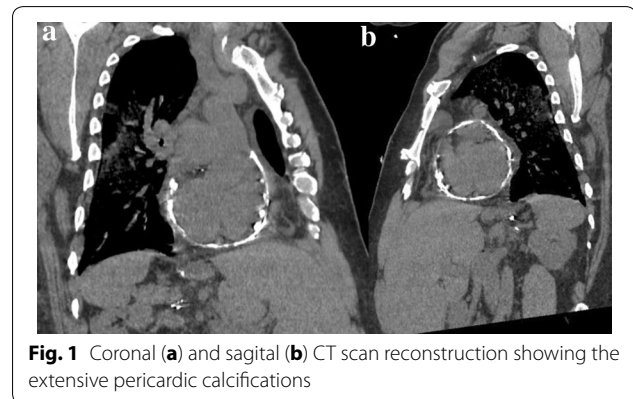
Coronal (a) and sagittal (b) CT scan reconstruction showing the extensive pericardic calcifications
